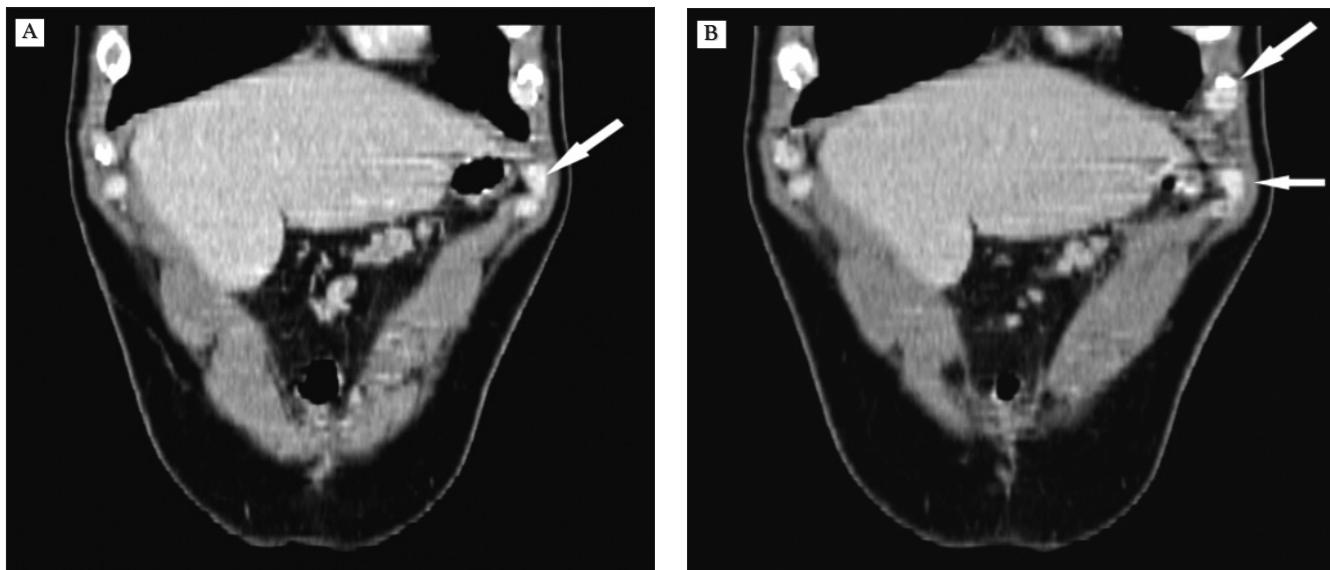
CT reconstruction – personal collection
